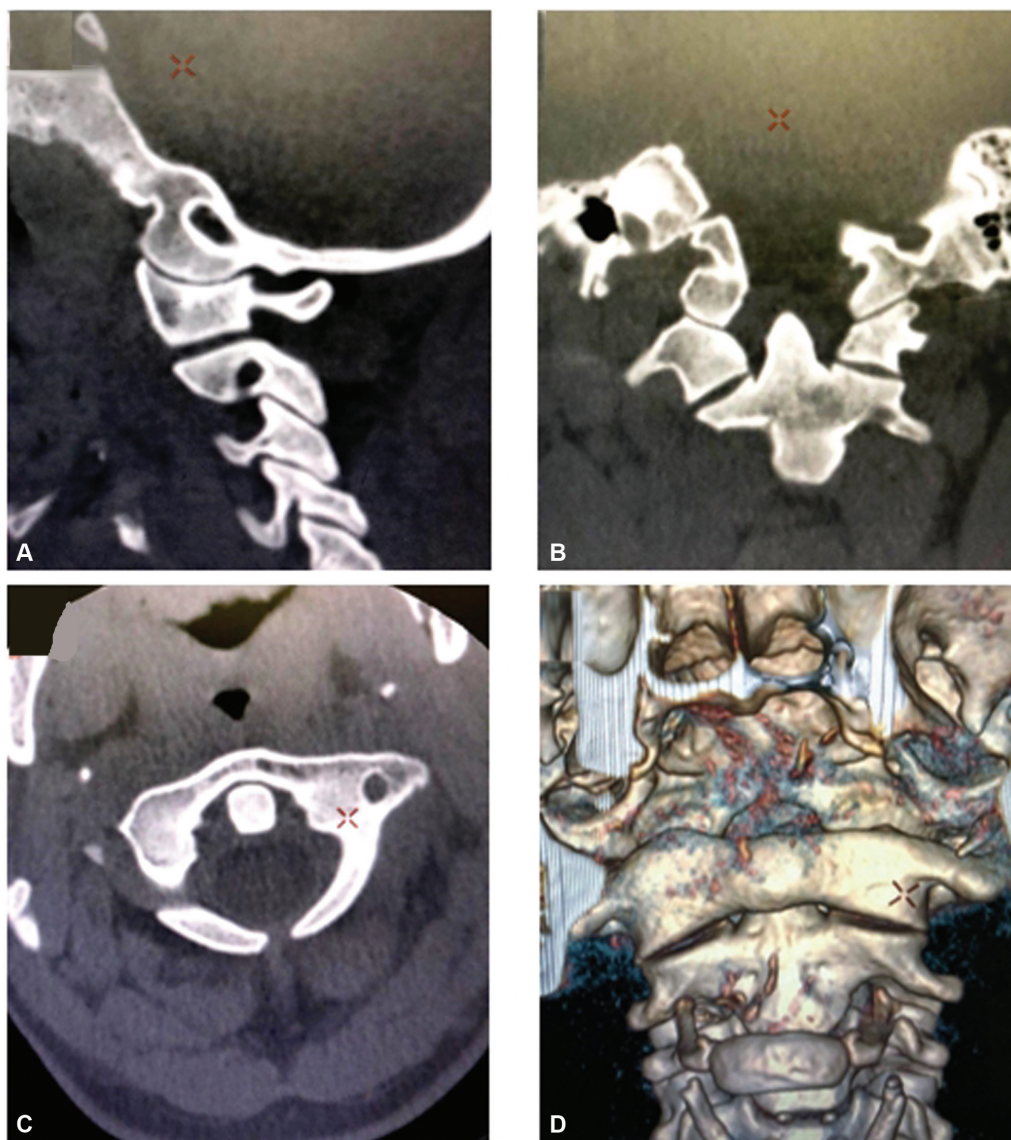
Computed tomography before reduction: (A) Right C1-C2 injured articulation (check the arrow); (B) Coronal cut; (C) Axial cut with right C1-C2 rotatory luxation; (D) Tridimensional reconstruction showing the C1 lateral mass luxation on the right in relation to C2.
